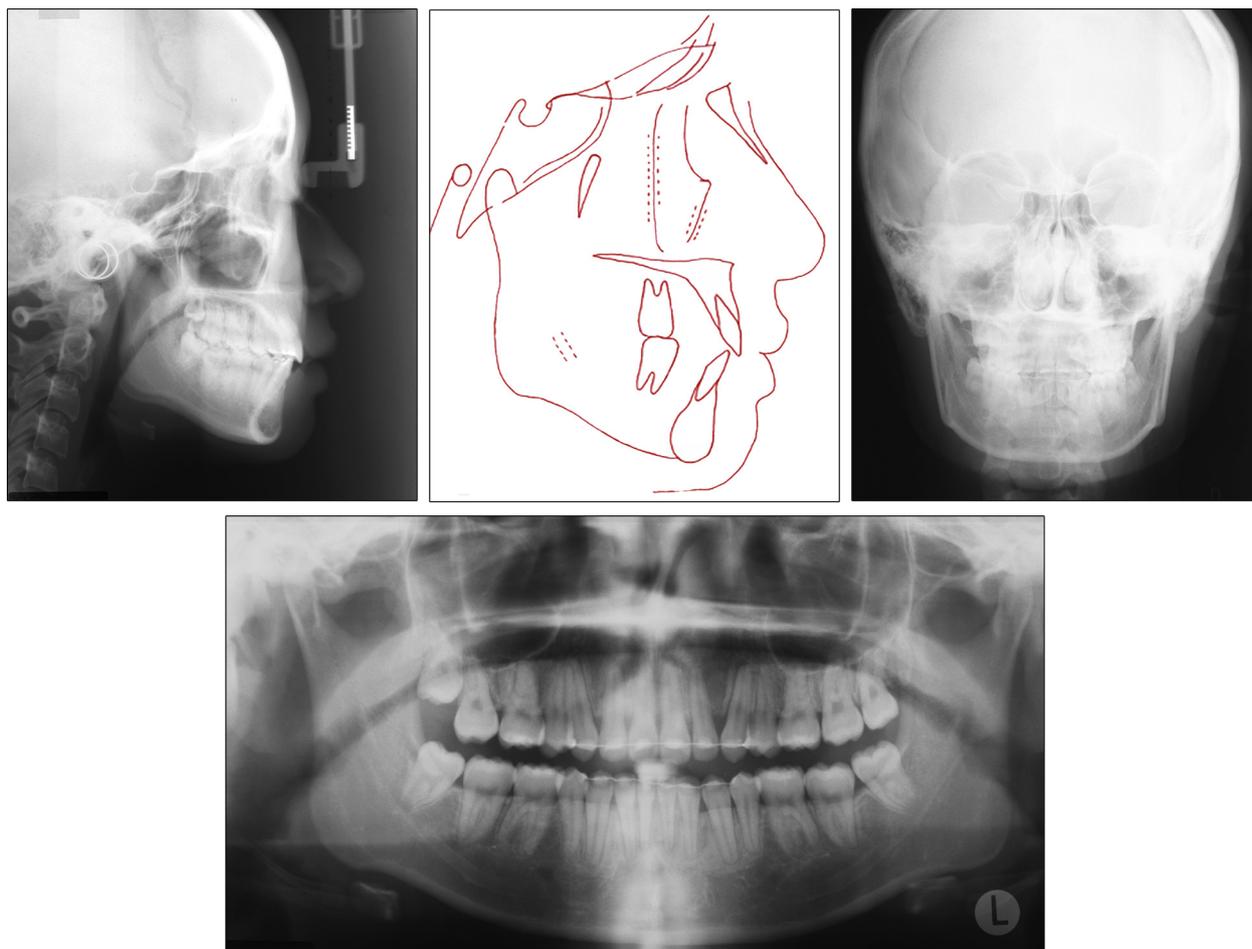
Posttreatment radiographs.
